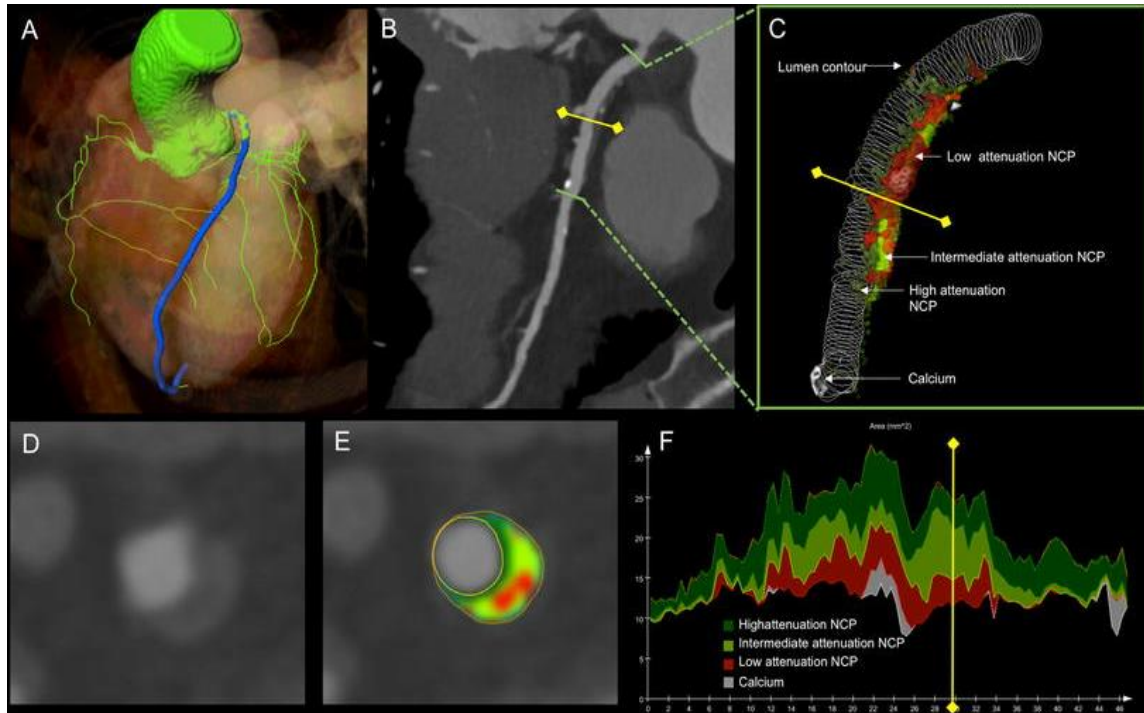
Semi-automated plaque assessment on CTA images (91).
